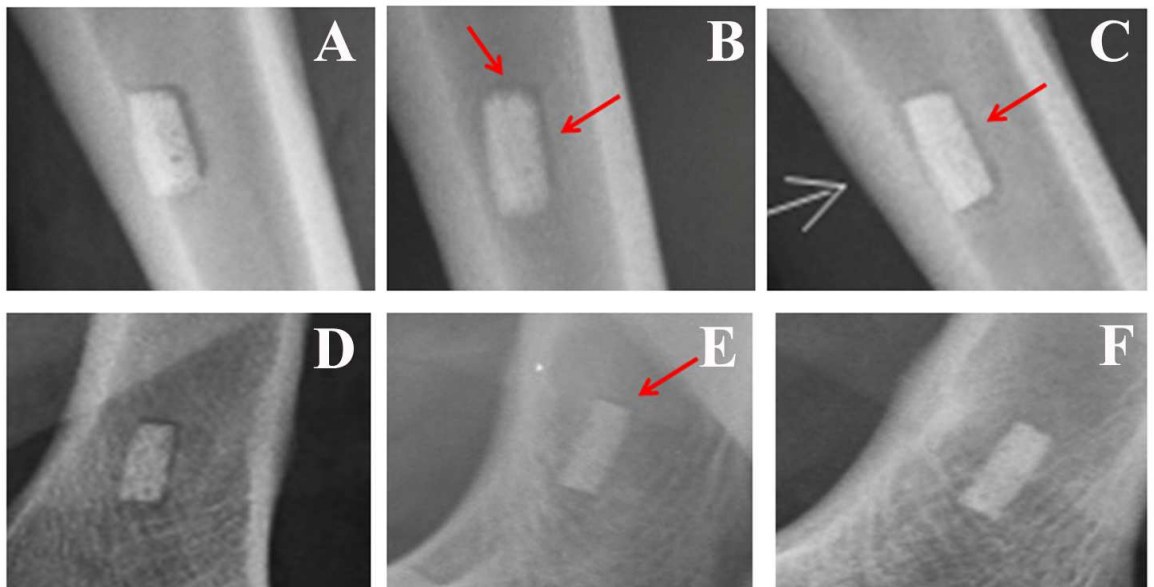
Evaluation of osteointegrative ability of the scaffolds – SrHA & cSrHA: Radiographs depict indicating the osteointegration ability post 0, 1, 2 months of implantation in SrHA (A-C) cSrHA (D-F). (Red arrow heads indicate poor osteointegration at bone implant interphase).
